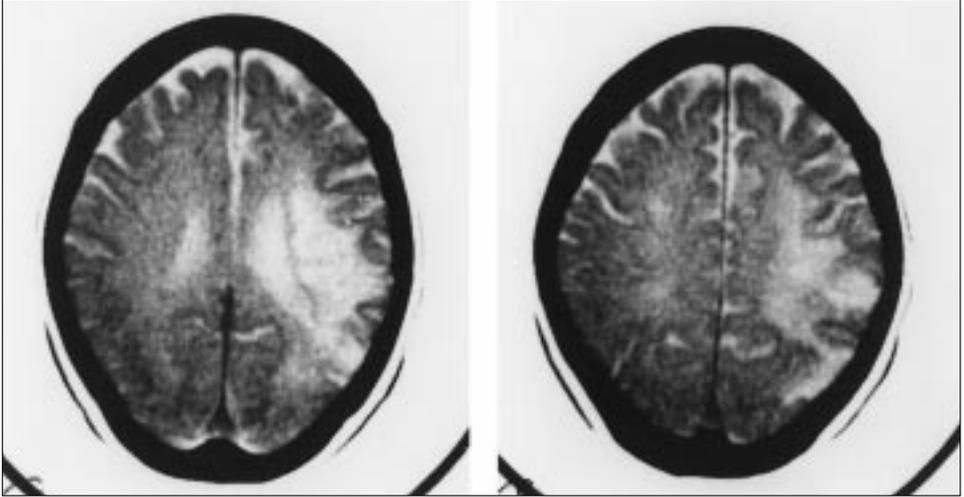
Computed tomography showing NG's left parietal infarct.
